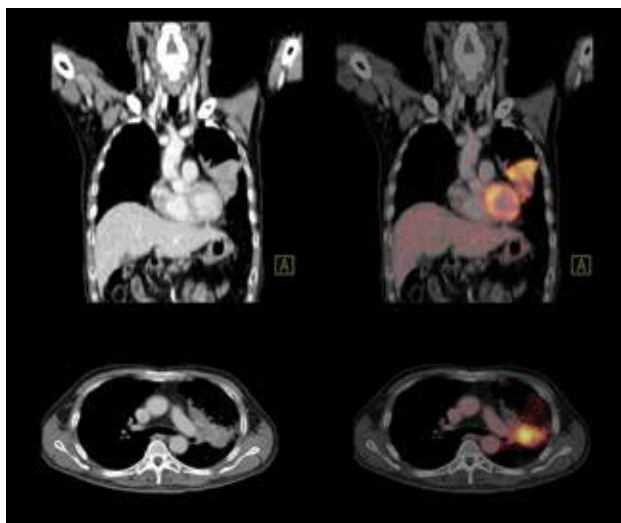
Contrast CT and fused PET/CT images show lobar consolidation with sharp delineation of lobar fissures and pneumonitis at the edges of the consolidation. Patchy hypermetabolism seen on fused PET/CT images reflect inflammation.
